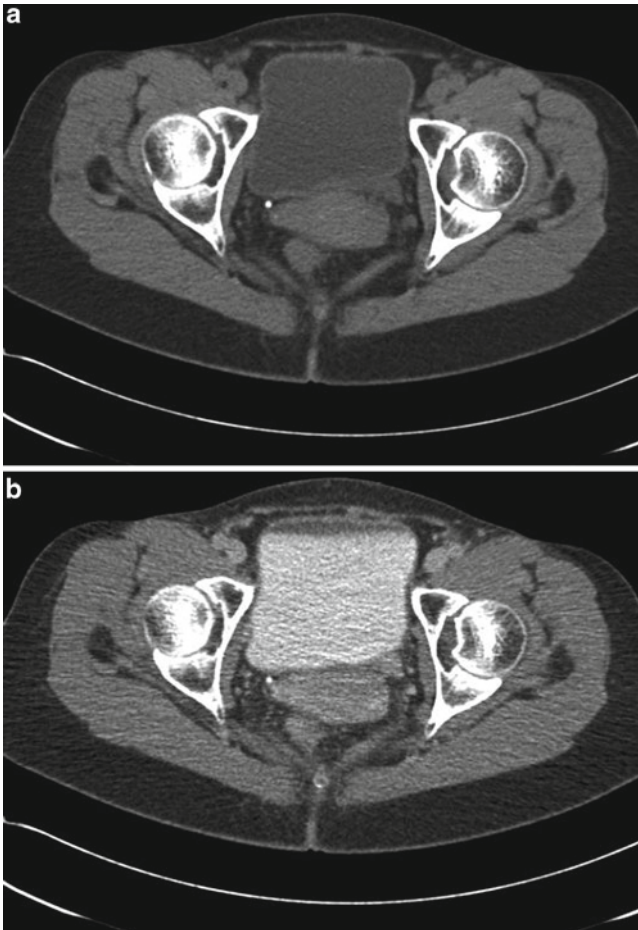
Showing the same tumor from Fig. 20.1 in contrast-enhanced CT. Solid tumor of the distal ureter. (a) Plain CT 15 HU, (b) venous phase 95 HU
